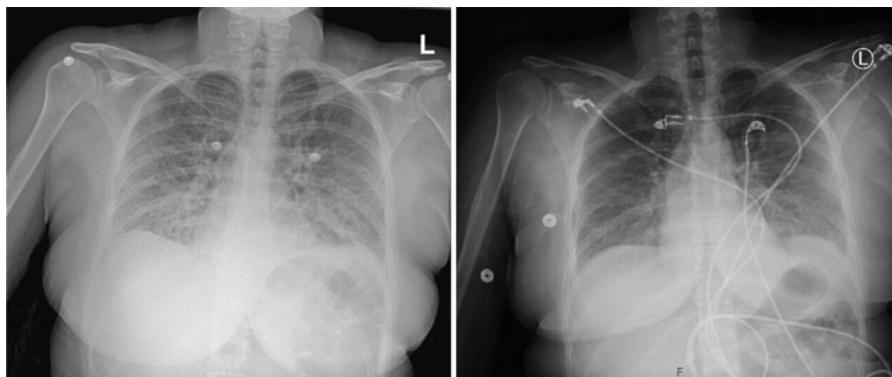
Chest radiographs from days 0 (left) and 1 (right), demonstrating rapid improvement of diffuse bilateral pulmonary edema.
